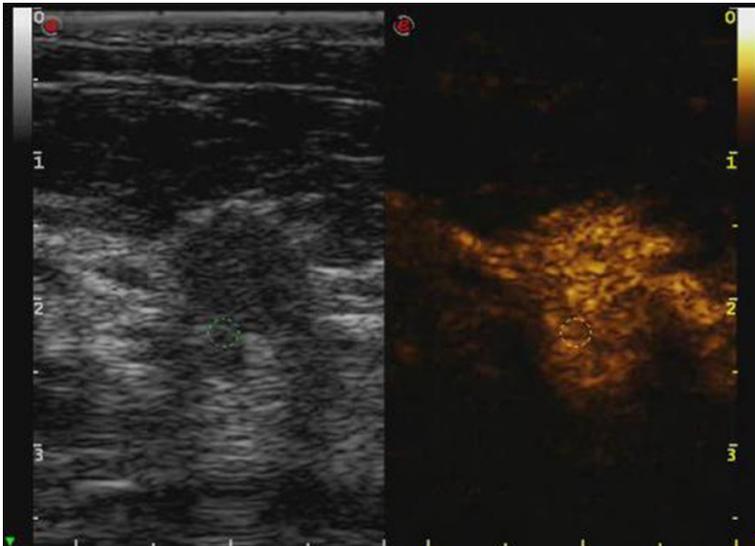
Double-image synchronous display of malignant breast lesion by contrast-enhanced ultrasound. The right contrast image showed heterogeneous high enhancement and burr margin, with significantly enlarged lesion area compared with the left two-dimensional image.
